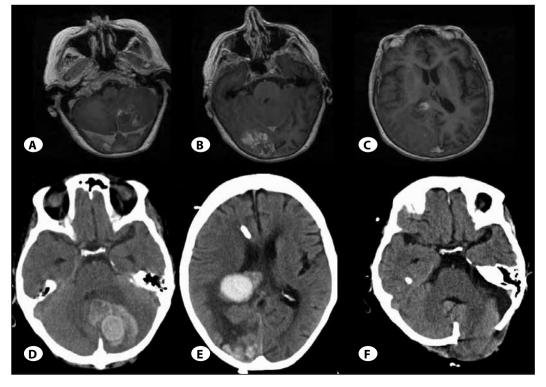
A-C) Gdenhanced T1W MRI shows hemorrhagic lesions identified in the left cerebellar, right occipital lobe and splenium. D) Non-contrast CT shows an increase in hemorrhagic lesion with mass effect and distortion of fourth ventricle. E-F) Following an interval resection of cerebellar lesion, there is persistent increased hyperdense area within the right parietal periventricular region.
